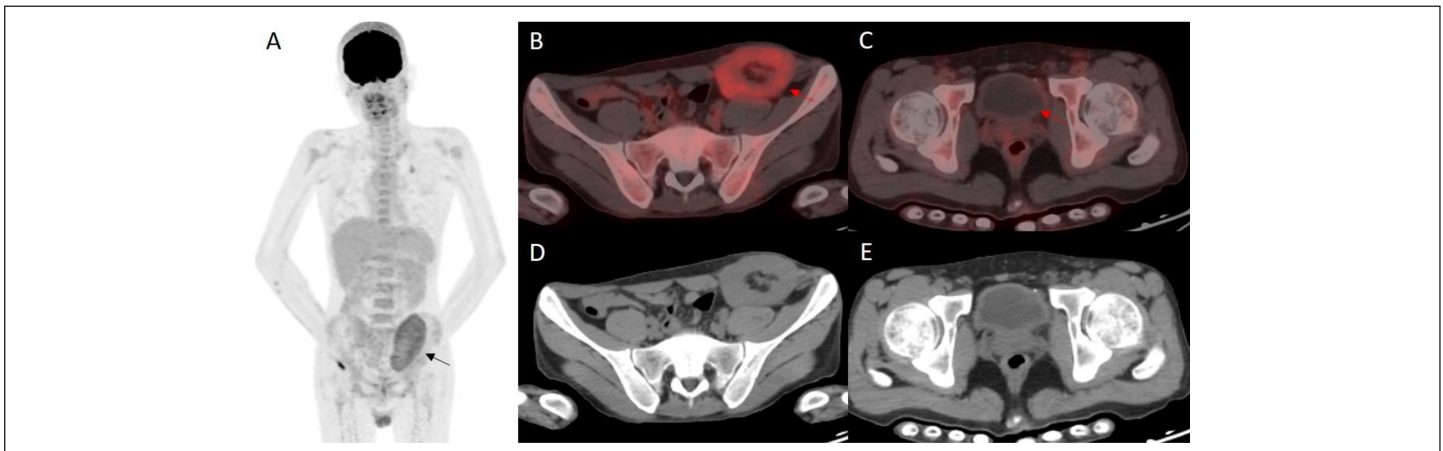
Moderate diffuse FDG uptake (SUVmax: 3.64) in the renal graft parenchyma was demonstrated in F18-FDG PET/CT maximum intensity projection (A: black arrow) and axial fused image (B: red arrow) with corresponding axial CT image (D). Lack of FDG uptake in the bladder was shown in the axial fused image (C: red arrow) with corresponding axial CT image (E).
